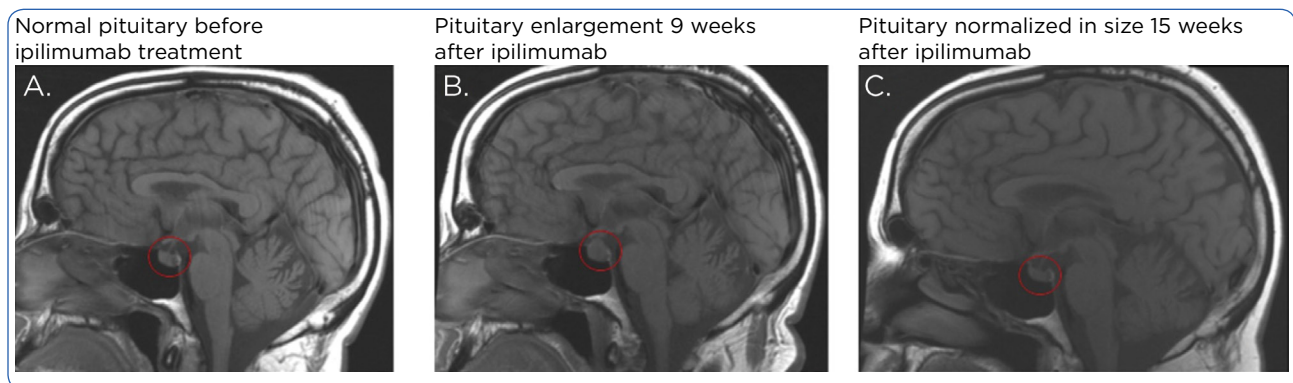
Brain magnetic resonance imaging with sellar cuts for initial and subsequent evaluation of patient with hypophysitis. Reproduced with permission from Min (2016).
